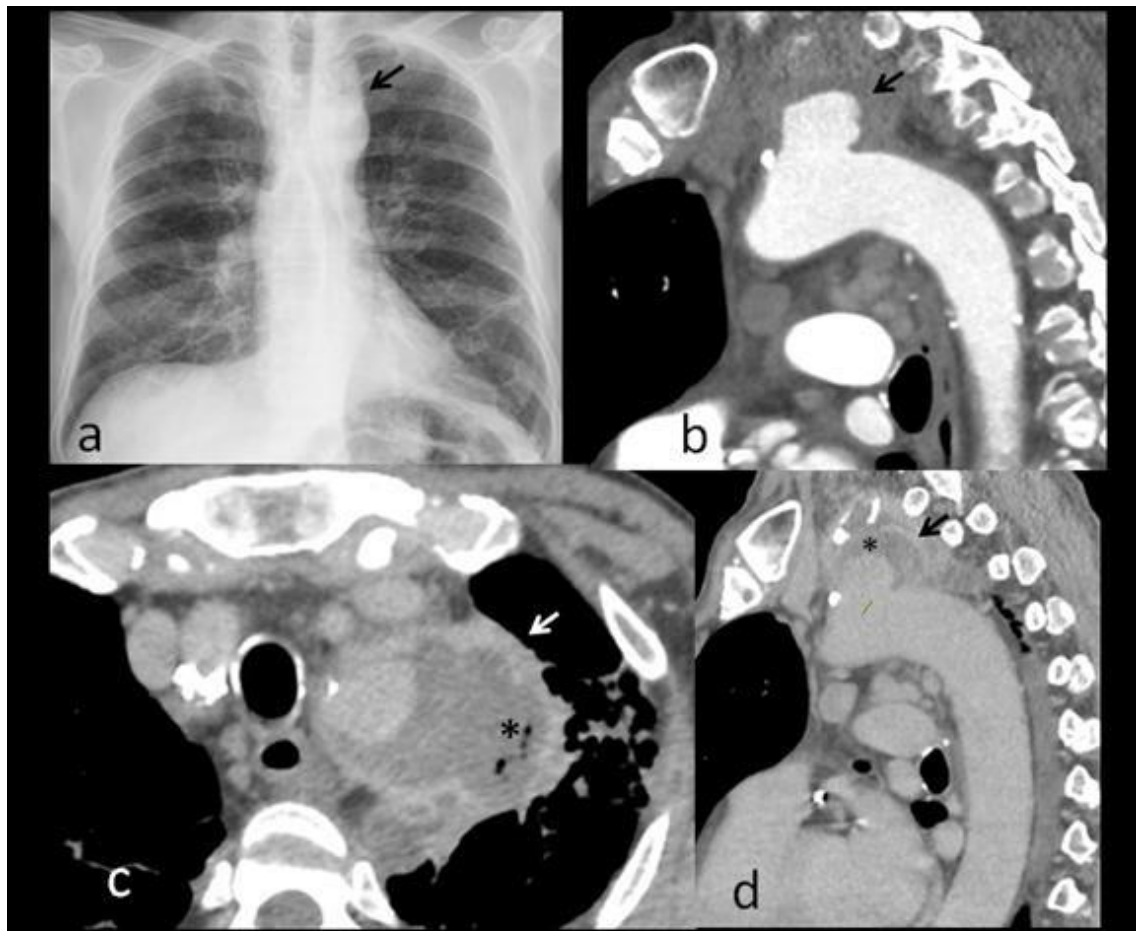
The anteroposterior chest x-ray showed an onset of a mediastinal lesion in contact with the aortic arch (figure a). A clear left upper lobe and a well-defined aortic-arch was seen in a previous one (performed 47 days earlier, not-shown); a month later a left upper lobe (LUL) opacity effacing the contour of the aortic arch appeared (not-shown), so a MDCT-angiography was done. The MDCT-angiography showed a pseudoaneurysm in the aortic isthmus (figure b, sagittal MDCTA arterial phase) surrounded by a hypodense collection which infiltrated the adjacent LUL parenchyma (asterisks in figure c and d, axial and sagittal MDCTA delayed phase). No contrast extravasations was seen, so no active-bleeding was suspected.
